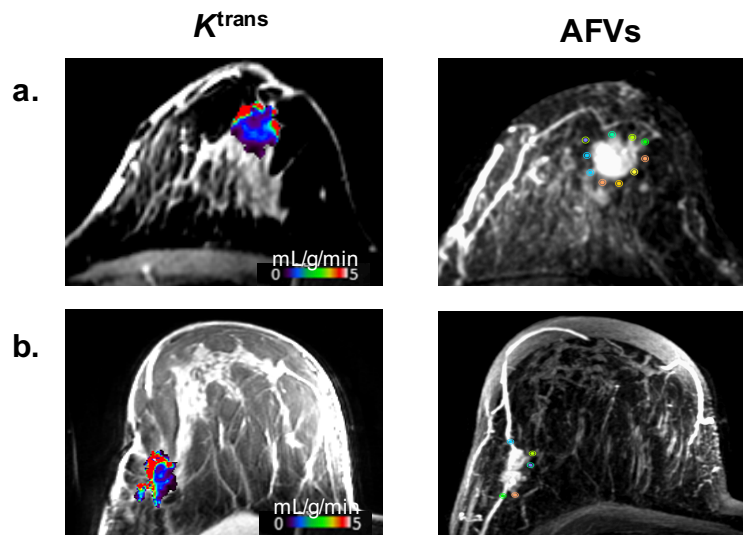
K^{trans} and adjacent feeding vessels (AFVs) of two invasive ductal carcinomas. The cancer in figure 4.2.a is bigger in size than the lesion in figure 4.2.b and therefore, it had more AFVs. Both cancers showed high K^{trans} in their periphery (area in red on K^{trans} maps) and lower K^{trans} in their centre (area in blue and purple on K^{trans} maps). Significant breast vessels can be observed on the subtracted axial DCE-MR images depicting AFVs.
